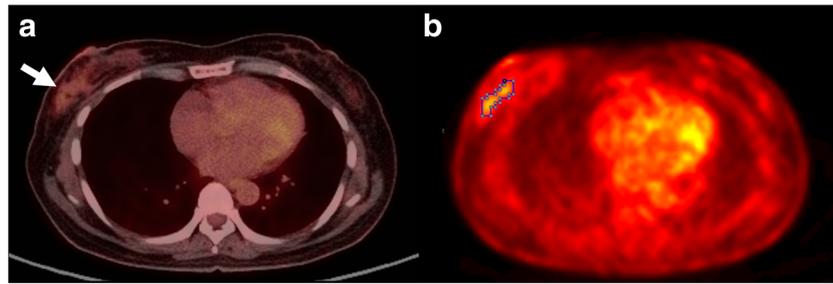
ER-positive/HER2-negative invasive ductal carcinoma in a 42-year-old woman. The pathologic invasive tumor size was 3.5 cm without lymph node metastasis (pT2N0). The nuclear grade was 2, and the IHC expression profiles were ER 40 %, PR 50 %, HER2 score 0, and Ki-67 12 %. a The preoperative ^{18}F -FDG PET/CT image shows mild ^{18}F -FDG
